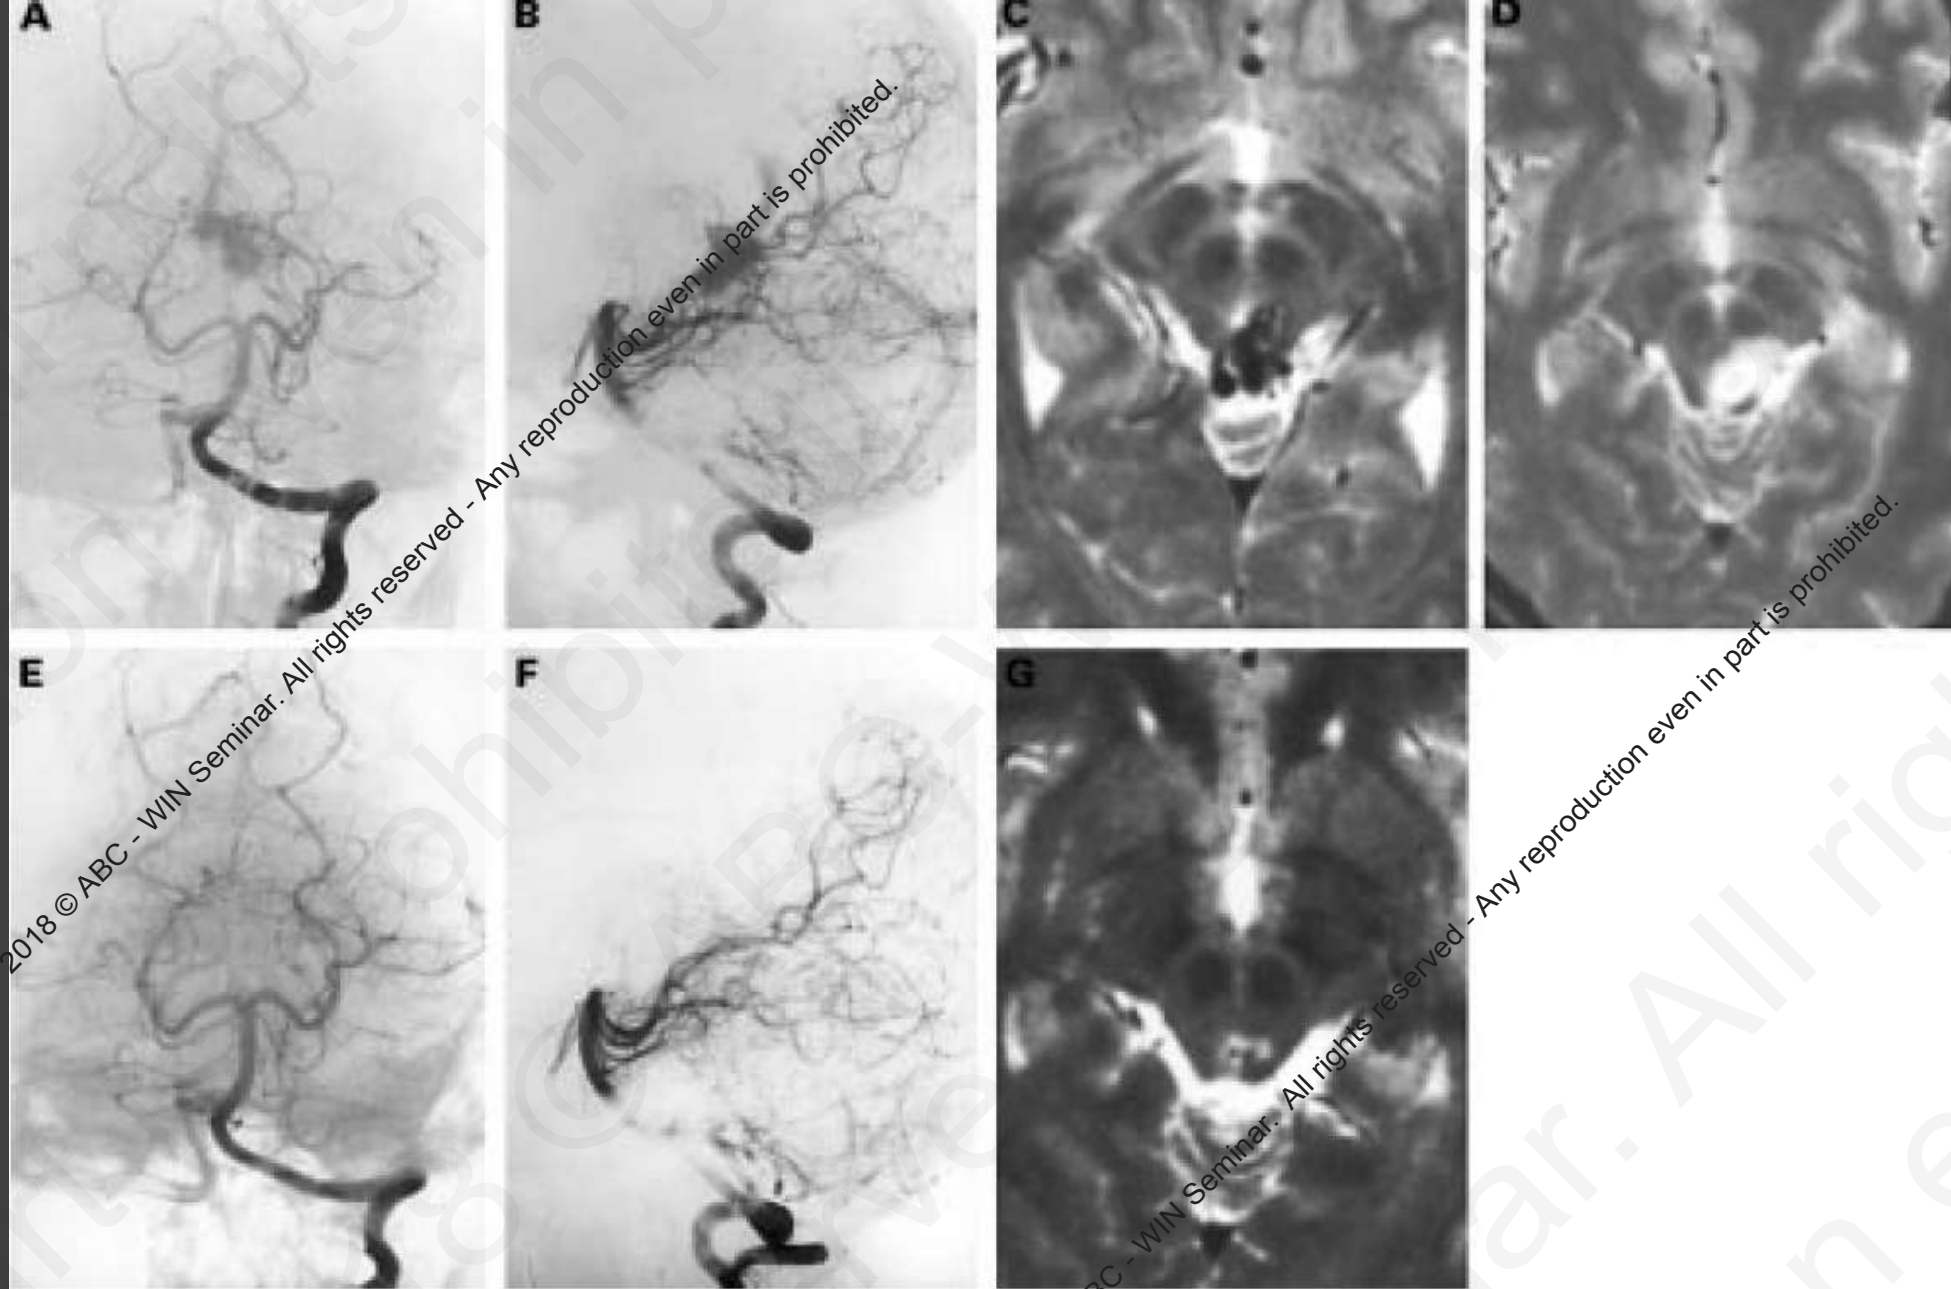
Neuroimages in a 16 year old girl with intraventricular haemorrhage. Left vertebral angiograms (A, B) and T2 weighted MR image (C) before radiosurgery show ruptured AVM in the tectum. T2 weighted MR image (D) obtained 6 months after radiosurgery shows asymptomatic brain stem oedema. Left vertebral angiograms (E, F) and T2 weighted MR image (G) obtained a year after radiosurgery show total obliteration of the AVM and a reversal of the oedema.
